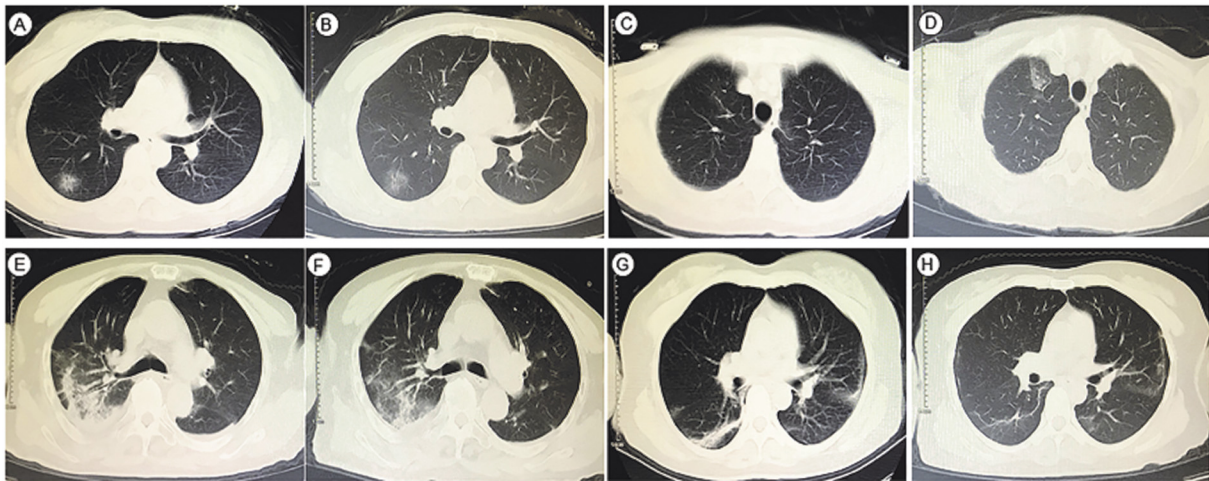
Representative images of the thoracic CT scans. A, C) CT scans of Case 1 on February 28th show opacities in the right lower lobes. B, D) CT scans of Case 1 on March 5th show new ground glass opacity in the right upper lobe. E) CT scan of Case 2 on February 25th shows a mixed pattern of ground glass opacities and consolidation. F) CT scan of Case 2 on March 5th shows lesion resolution. G) CT scan of Case 3 on February 16th shows multiple patchy high density shadows of both lungs. H) CT scan of Case 3 on March 6th shows resolution.
